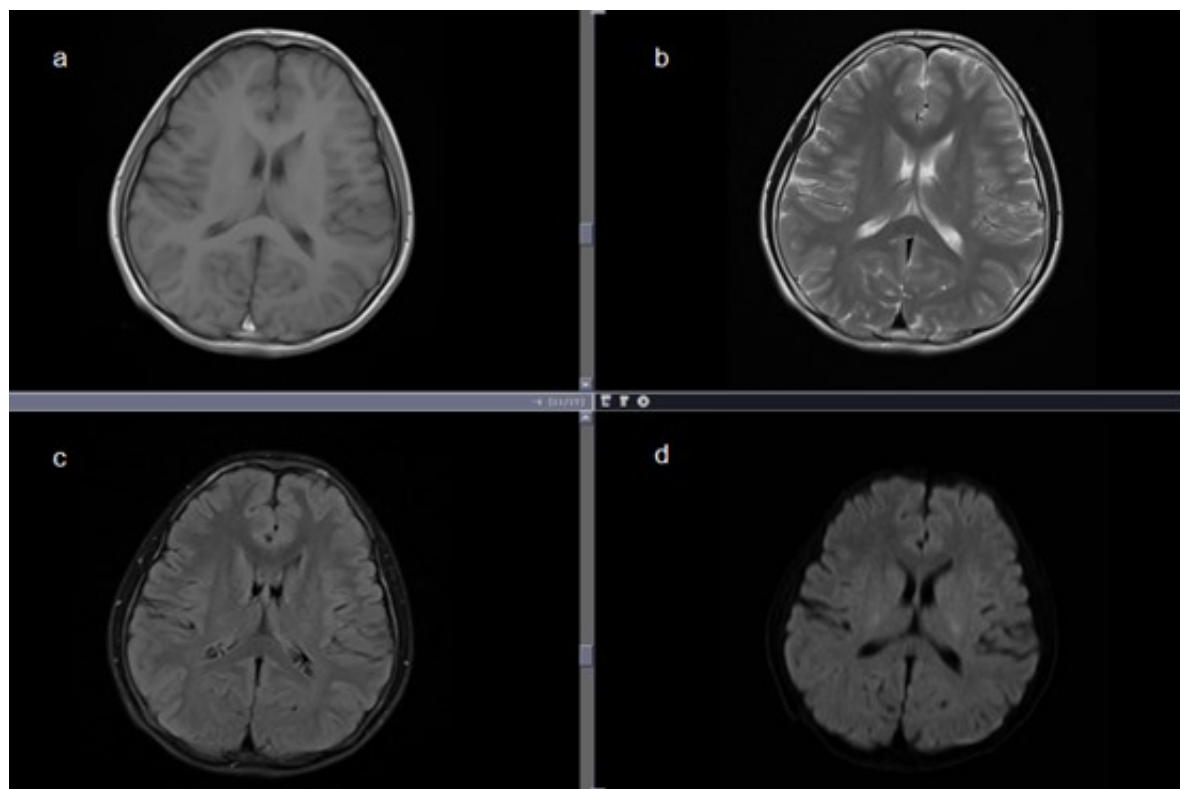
At 9 days after first MRI, second MRI showed abnormal signals of the splenium of corpus callosum completely disappearing onT1WI (a), T2WI (b), FLAIR (c) and DWI (d).
